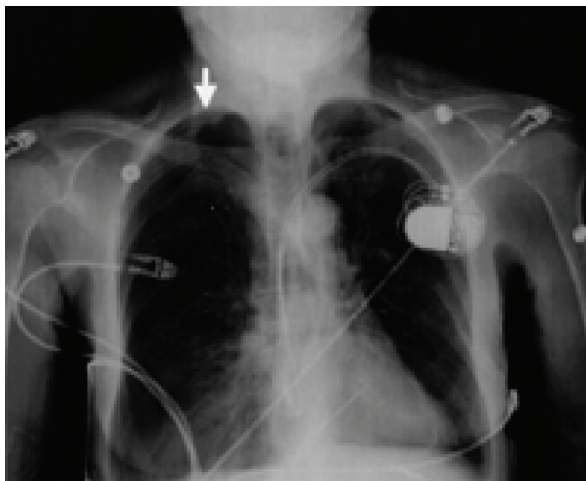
Chest X-ray showing right pneumothorax (arrow) 8 h after placement of a left-sided permanent dual chamber pacemaker.
